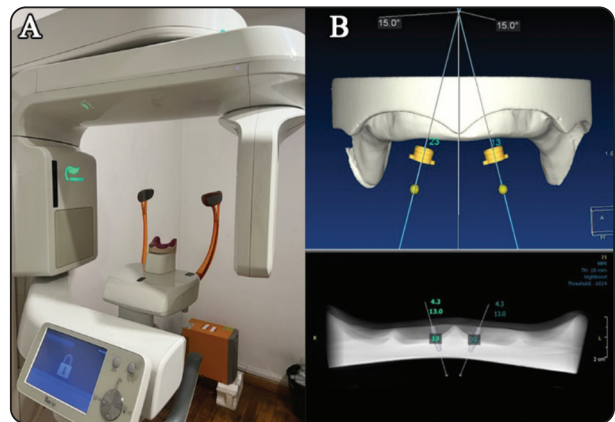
(A) Scanned epoxy model obtained by cone beam computed tomography (CBCT) (Green Veatch). (B) Virtual Planning of Implants to be 15 Degree Distal Inclination for Each Implant
